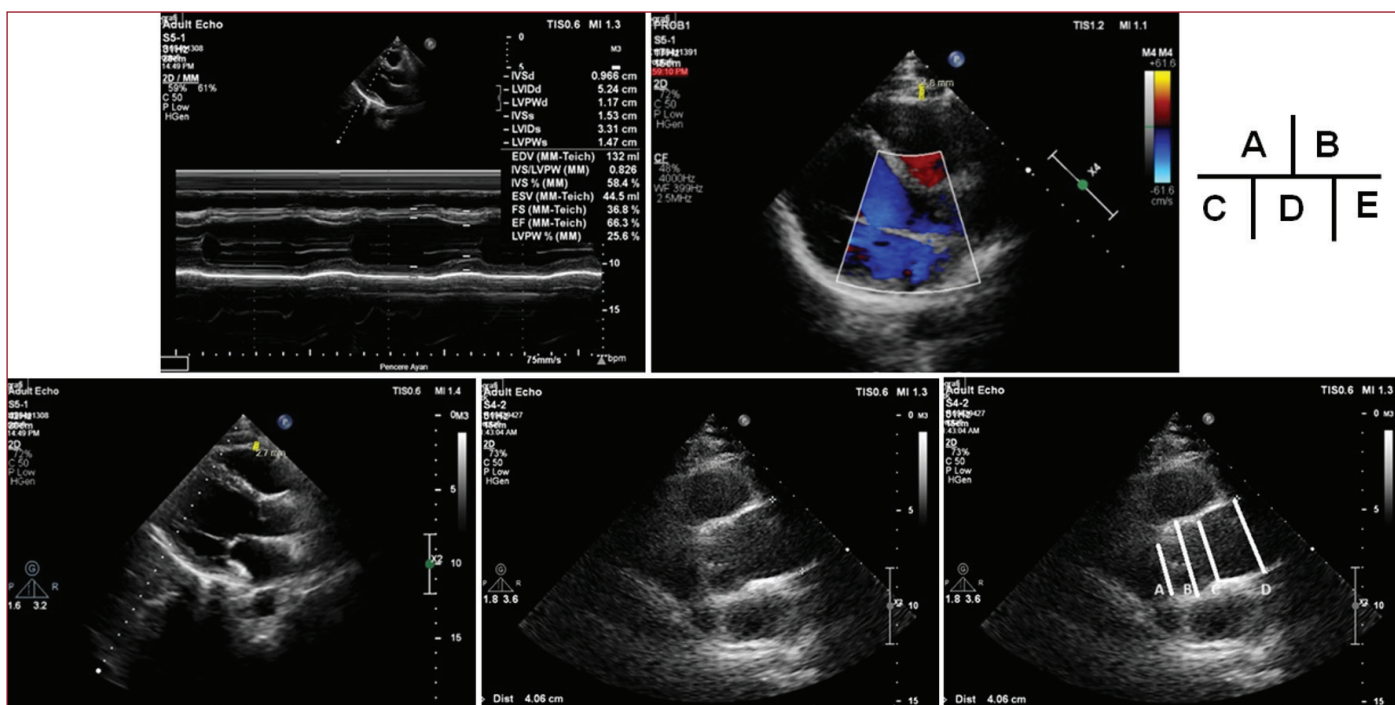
A) Echo measurements of the left ventricular septum, posterior wall, end-diastolic diameter, end-systolic diameters, and ejection fraction from the parasternal long axis with M-mode. B) Measurement of epicardial fat tissue from the parasternal long axis at the level of the aortic valve projection from the RV free wall at the end of diastole. Measured 4.8 mm in the sample. C) Measurement of epicardial fat tissue from the parasternal long axis at the level of the aortic valve projection from the RV free wall at the end of diastole. Measured 2.7 mm in the sample. D) Measurement of the ascending aorta. E) The way of the measurement is shown as below. A: Aortic root; B: Sinus valsalva; C: Sinotubular junction; D: Ascending aorta.
